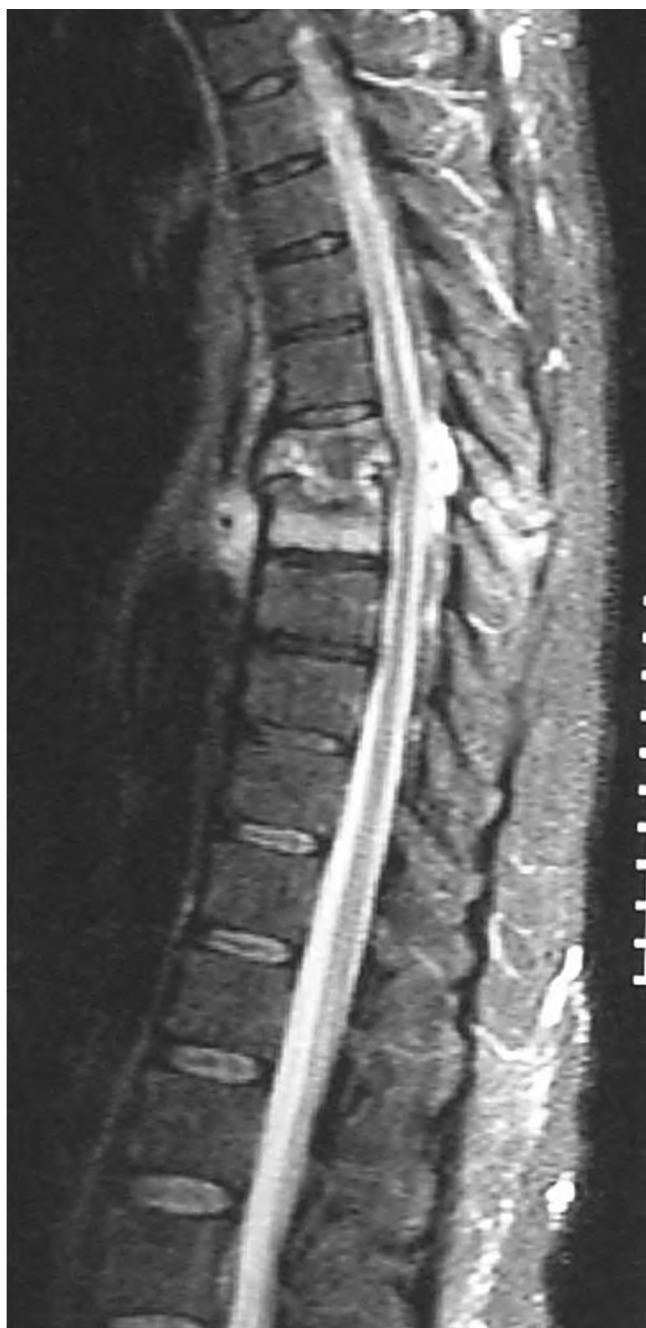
MRI demonstrating vertebral osteomyelitis T7 and T8 with kyphotic deformity and destruction of vertebral body T7.
